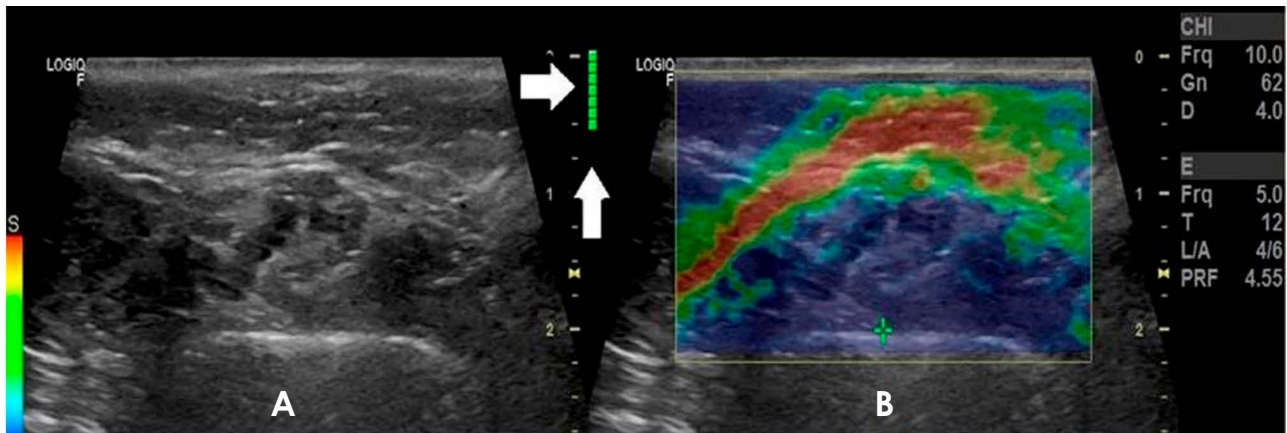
A. A normal ultrasound image of the masseter muscle. B. An ultrasound elastography image of the same masseter muscle as shown in image A. The elasticity scale indicates the optimal degree of compression in the elastogram, which is entirely green (indicated by the white arrow).
